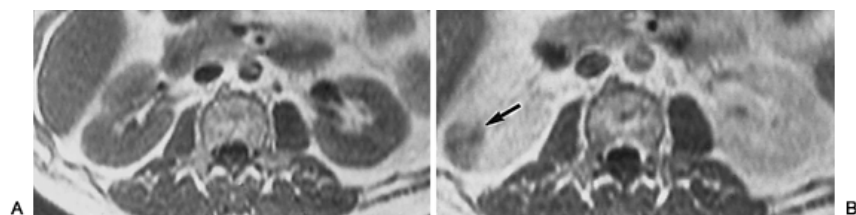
13. Role of magnetic resonance imaging (MRI) in detecting renal infection in an immunocompromised patient. This patient was immunocompromised as a result of aplastic anemia. Previous exposure to nephrotoxic antibiotics had impaired his renal function. A: Precontrast T₁-weighted image shows no detectable abnormality. B: Postcontrast T₁-weighted image demonstrates a focal defect in the periphery of the right kidney (*arrow*). Subsequent percutaneous biopsy demonstrated cryptococcus.
